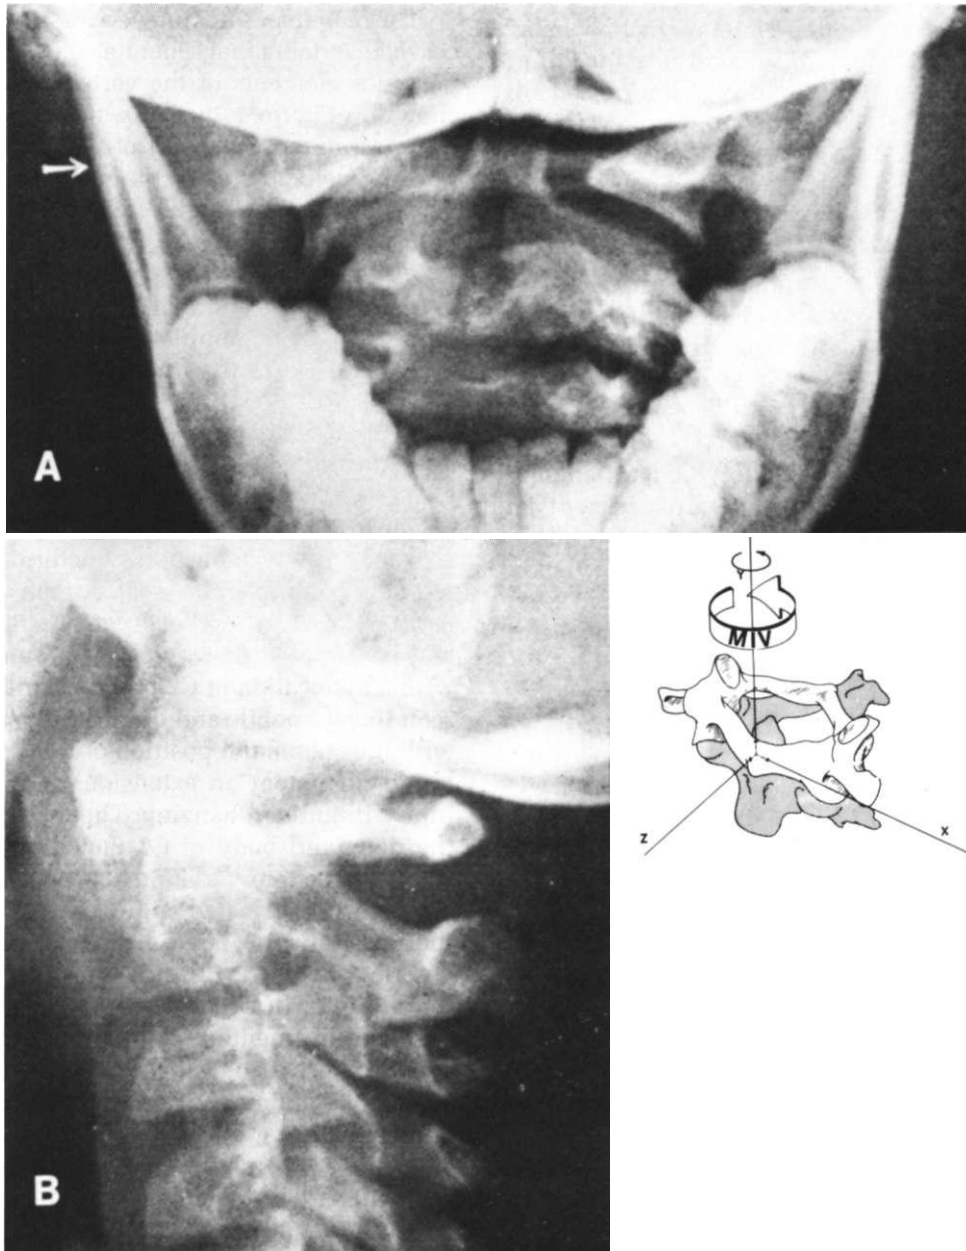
A rotary subluxation of C1 on C2. (A) The arrow indicates an overlap of the lateral mass of C1 in relation to the articular facet of C2. This overlap occurs as a result of lateral as well as anterior displacement. (B) On the lateral view, one can see an abnormal displacement between the anterior portion of the dens and the posterior portion of the anterior ring of C1. The MIV for this type of injury is primarily a moment about the y-axis, as shown in the inset. (Radiographs from Garber, J. N.: *Abnormalities of the atlas and the axis: vertebral, congenital and traumatic*. *J. Bone Joint Surg.*, 46A:1782, 1964.)
